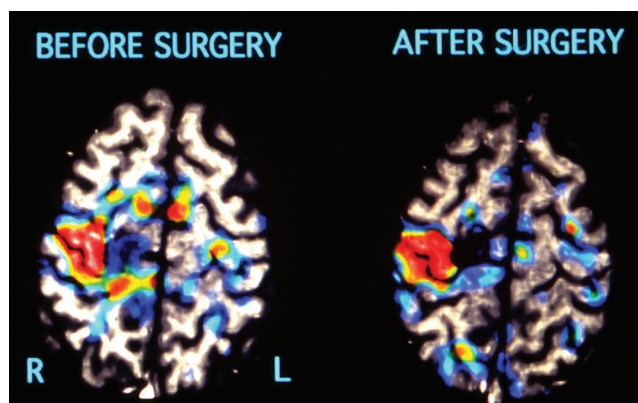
H_2^{15}O PET activation study of the cortical network involved in left hand movement in a patient before (left) and after surgical resection of a cavernoma located in the close vicinity of the left hand motor area. Each image is the difference between 60 sec duration scan acquired after intravenous infusion 6 mCi of H_2^{15}O either with or without movement of the left hand fingers. Difference images are superimposed on the subject structural MRI. Note that the surgery spared the hand motor area but an activation focus on the midline disappear after surgery showing that premotor area has been disconnected from the motor area. (R, right; L, left). Courtesy GIN, CEA, Orsay
